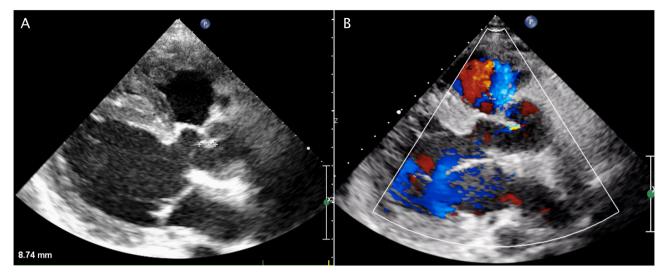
Postoperative echocardiographic view, showing (A) adequate coaptation height (8.74 mm) with (B) trivial aortic regurgitation.
